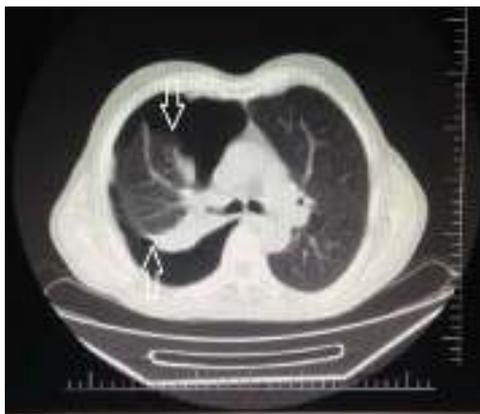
the patient's chest CT image- pneumothorax line indicated by arrow
